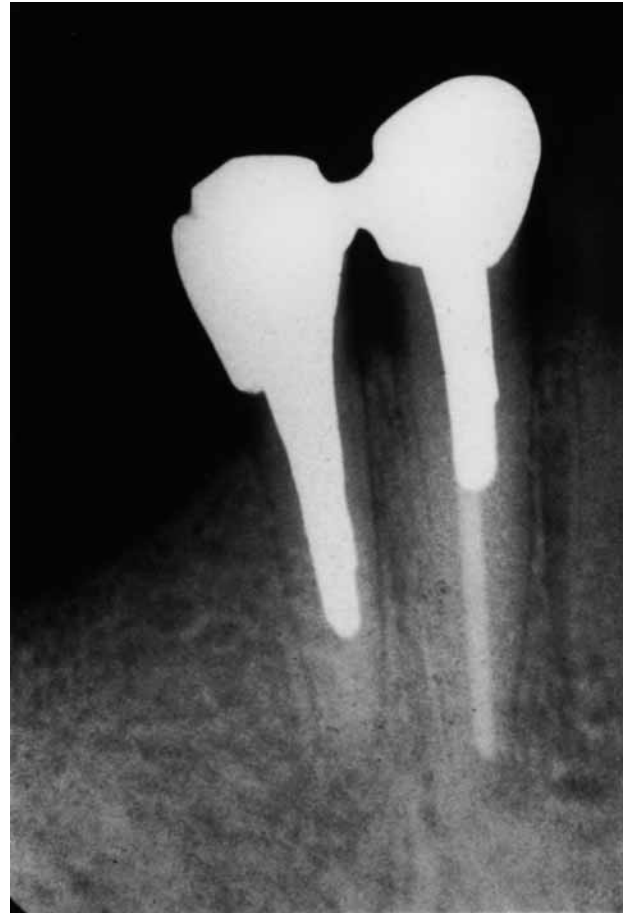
Pre-treatment radiograph of mandibular right first premolar with vertical root fracture shows no bone loss.
